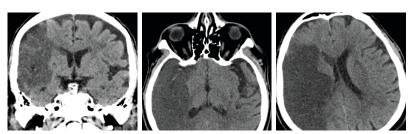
Head CT scan performed 24 hours after thrombolysis showed a large ischaemic stroke in the right MCA territory
